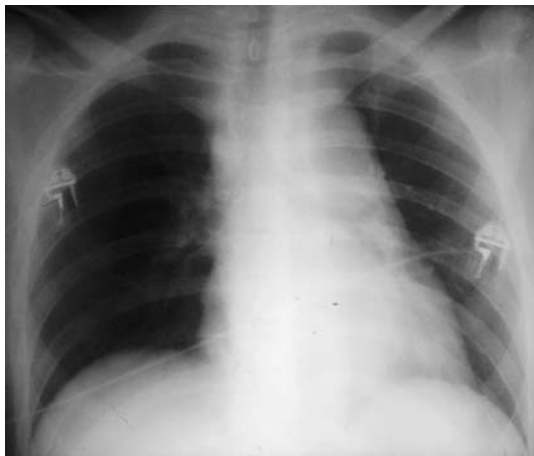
Chest X-ray. Mediastinal widening (>10 cm), with enlargement of the paratracheal stripe. The apical cup sign is visible at the left apex due to hemorrhage of the epiaortic vessels. A slight deviation of trachea to the right and inferior displacement of left mainstem bronchus are also present.
